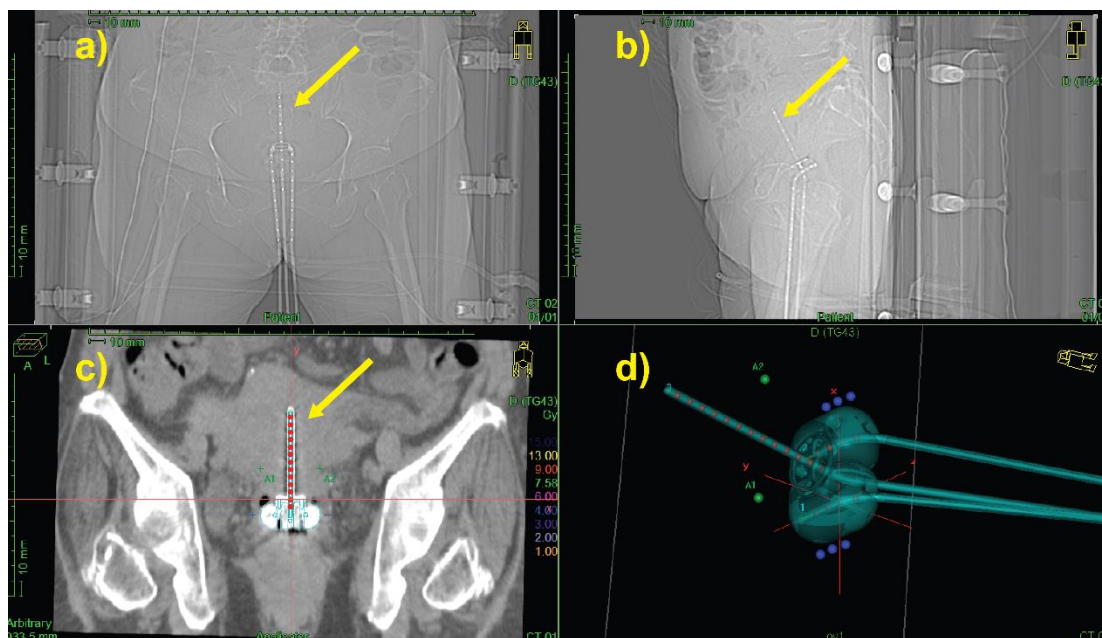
(a) and (b) shows the topogram of the patient with the Rotterdam cervix applicator and 2 ovoids. (c) shows the applicator model and the radiation seeds position in the CT image (d) shows the applicator model created with red circles defining the radiation seeds position and blue circles represent the optimization points.
